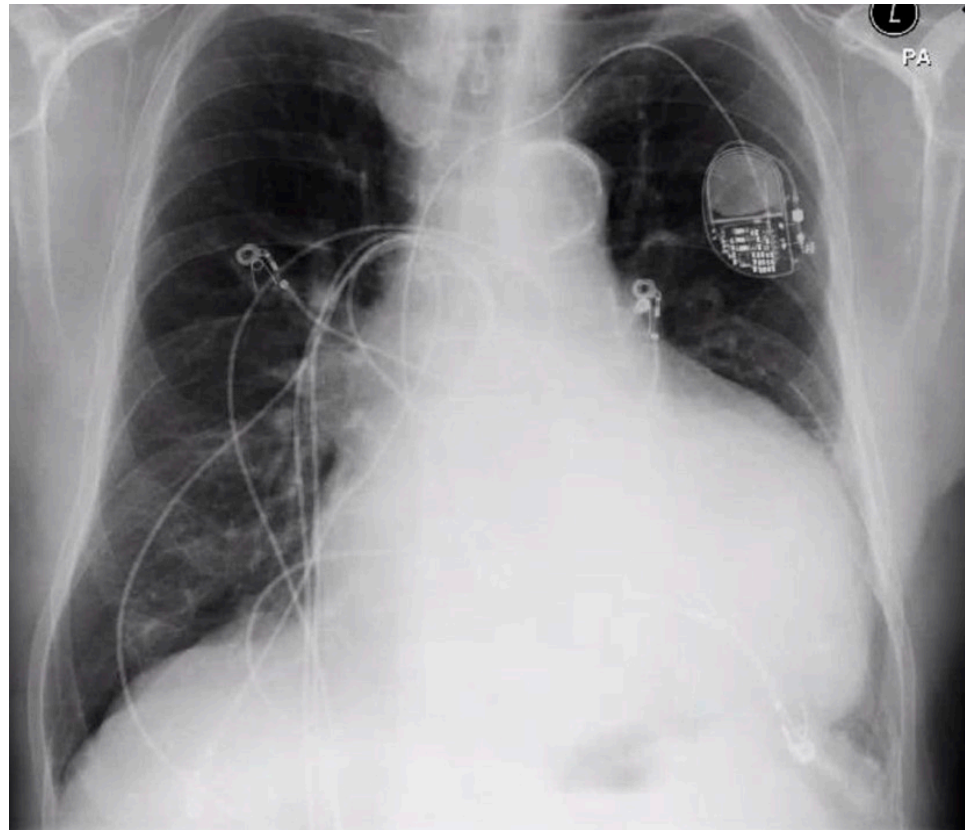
Chest X-ray evidencing an enlarged cardiac contour.
